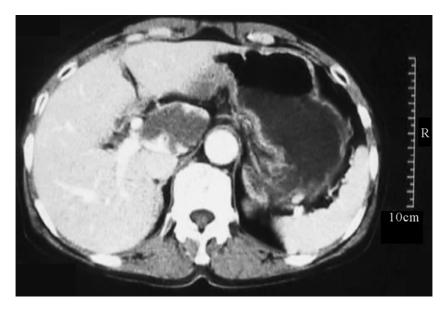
CT showing a hemangioma in the caudate lobe
